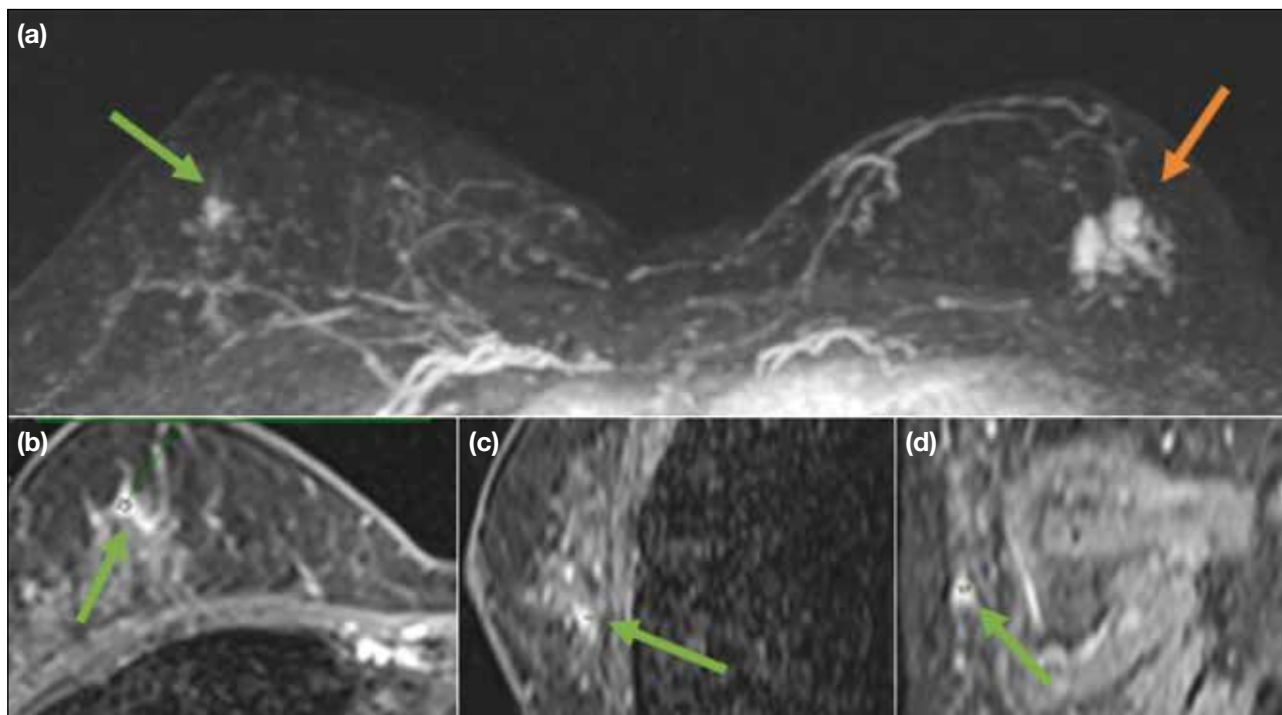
A 63-year-old woman with bilateral breast carcinoma detected by preoperative magnetic resonance imaging, prior to bilateral mastectomy. (a) T1-weighted three-dimensional reconstructed subtraction axial image shows the primary tumour (invasive ductal carcinoma) as an enhancing lobulated mass in the left breast (orange arrow) and an incidental finding of focal non-mass enhancement (NME) in the right breast (green arrow). (b) Reformatted T1-weighted post-contrast image of the right breast shows focal NME (green arrow), which was confirmed to be ductal carcinoma in situ by ultrasound-guided biopsy. Reformatted sagittal (c) and coronal (d) post-contrast T1-weighted images with subtraction (green arrows).
